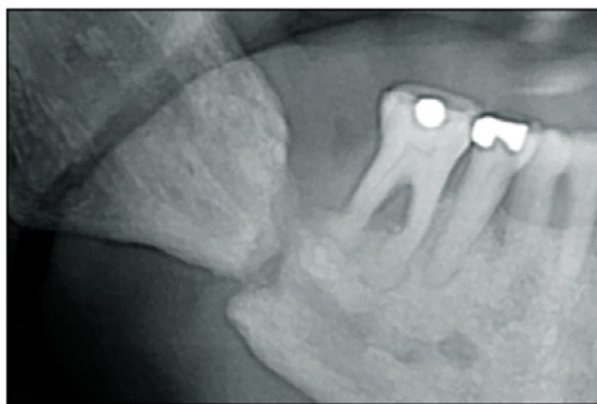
This radiograph shows a pathologic fracture of the right mandible secondary to osteoradionecrosis. The patient had received radiation therapy to the oral cavity in the past for oral cancer.
